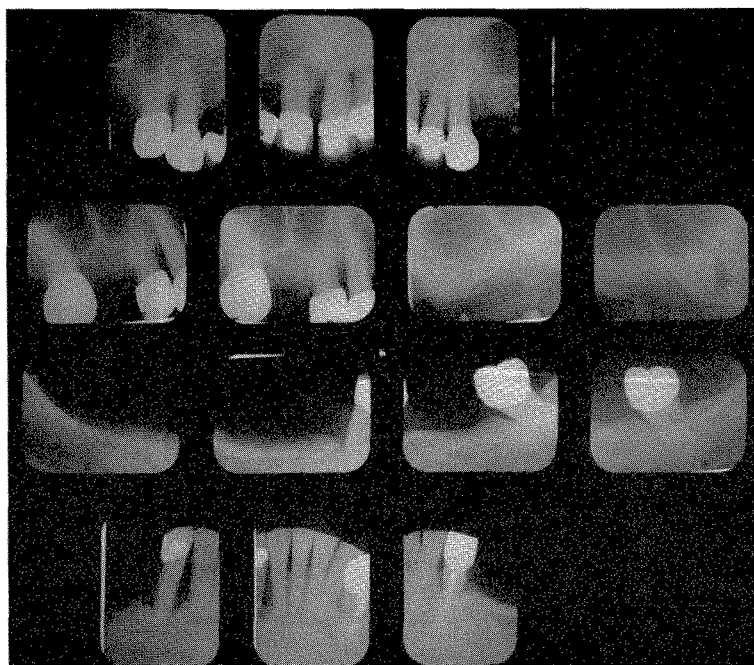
Roentgenograms taken in November, 1955.
